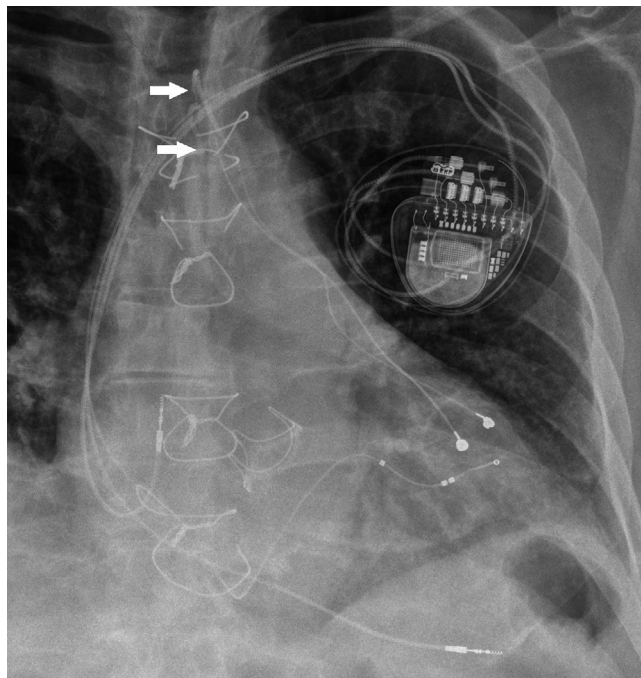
Focused postprocedure chest x-ray after the cardiac resynchronization therapy device implant in 2018 with three transvenous leads in the right atrium, right ventricle, and left ventricle via the coronary sinus, respectively. The abandoned part of the epicardial left ventricular lead was completely fractured at the suprasternal notch (superior arrow) with an isolated short extrathoracic subcutaneous fragment that also was severed from the explanted part of the lead at the level of one of the fractured sternal wires (inferior arrow)
